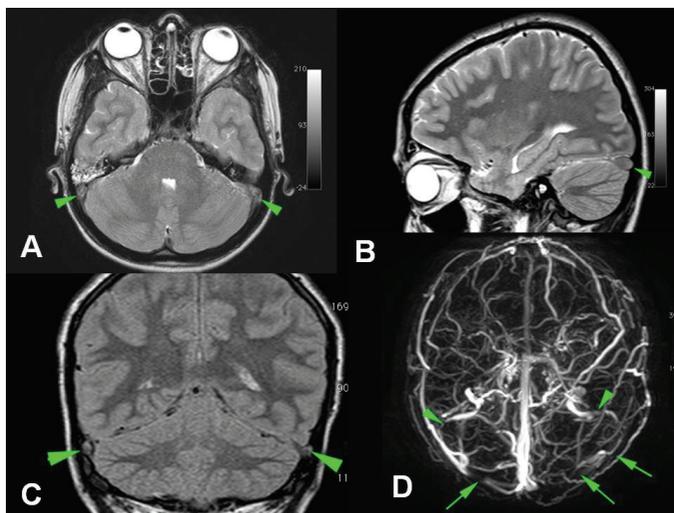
Magnetic resonance imaging before anti-TNF (A-D) of a 21-year-old female patient with dural venous sinus thrombosis diagnosed with Behçet's. Axial T2-weighted MR (A), sagittal T2-weighted MR (B), and coronal FLAIR (C) images show thrombus in bilateral transverse sinuses (arrowhead). A magnetic resonance venography (D) shows thrombus in bilateral transverse sinuses (arrow) and sigmoid sinuses (arrowhead)
